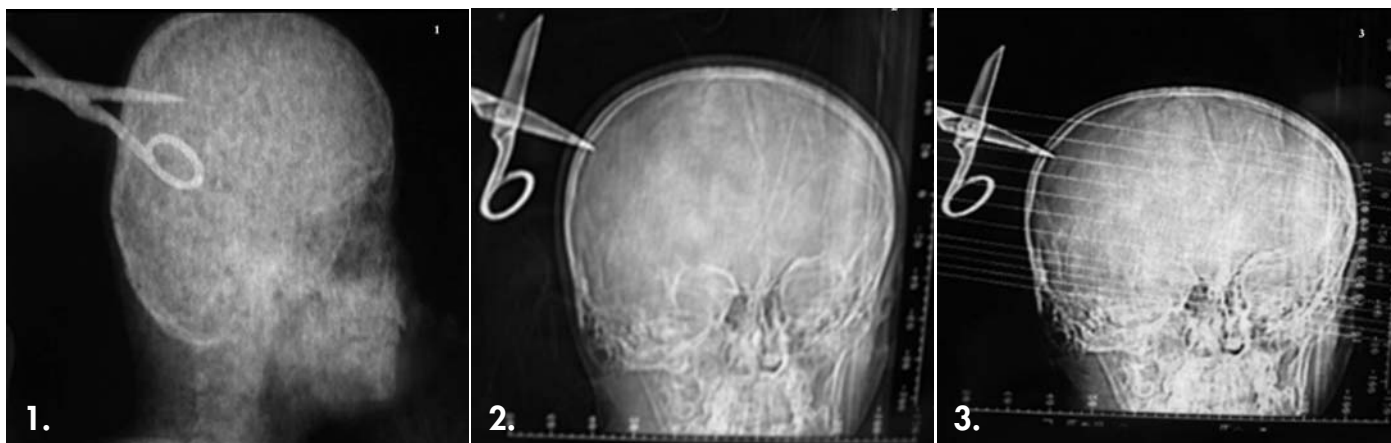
3 Cranial lateral X-ray (Figure 1) and cranial computed tomography (CT) (Figure 2,3) demonstrated a hyper dense foreign body (scissors) penetrating cranial cavity and ended before reaching posterior region of the left parietal lobe.
